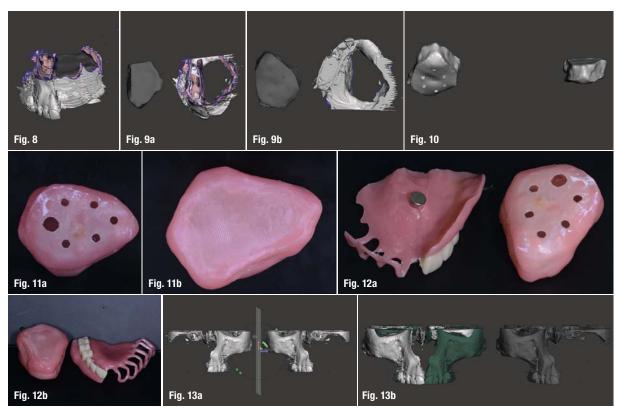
Digital maxillary dentition and the segmented CBCT data uploaded to Meshmixer software. Fig. 9a: Obturator fabricated using the Meshmixer software. Fig. 9b: Hollow obturator. Fig. 10: Initial obturator design. Fig. 11a: Printed hollow bulb obturator. Fig. 11b: Top side of the obturator. Figs. 12a & b: Definitive prosthesis. Fig. 13a: Mirrored digital maxillary left dentition using CBCT data. Fig. 13b: Complete digital maxillary dentition using CBCT data.
